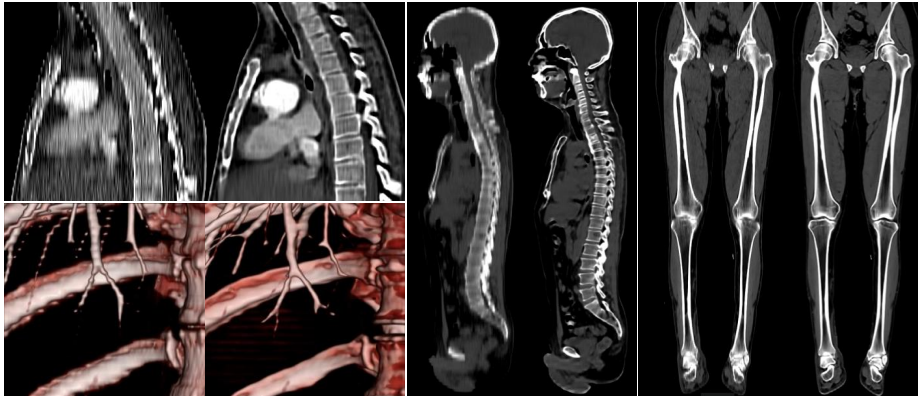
Comparison of original thick image and the virtual thin image output generated by the proposed approach. On the left top row, the CT sagittal view of original thick image is blurred with each vertebrae bone being nearly indistinguishable, while they become clear in corresponding $\times 8$ super resolution image (Virtual Thin). Arbitrary size data, even the whole body shown on the right, is available for inputs and capable of reconstructing natural image regardless of body part. On the left bottom row, fine blood vessel are smoothly reconstructed in a volume rendering view.
